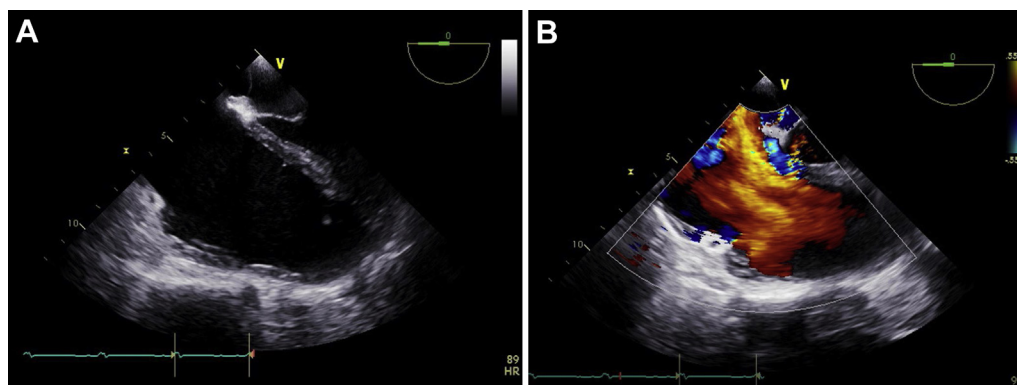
(A) Midesophageal four-chamber view showing surgical valvulotomy, ventricularized right heart, dilated right ventricle and right atrium, and interatrial septal bowing. (B) Color flow Doppler of right ventricle shows wide-open regurgitant flow through remnant TV.
